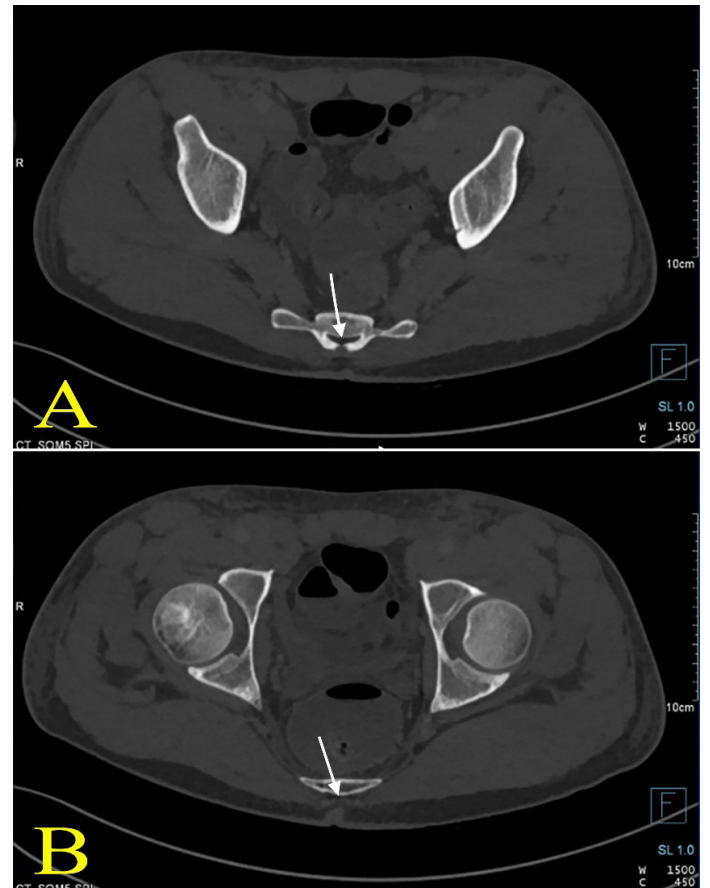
LHS measurement on axial CT. A. Hiatus sacralis starting place, B. Hiatus sacralis ending point.
